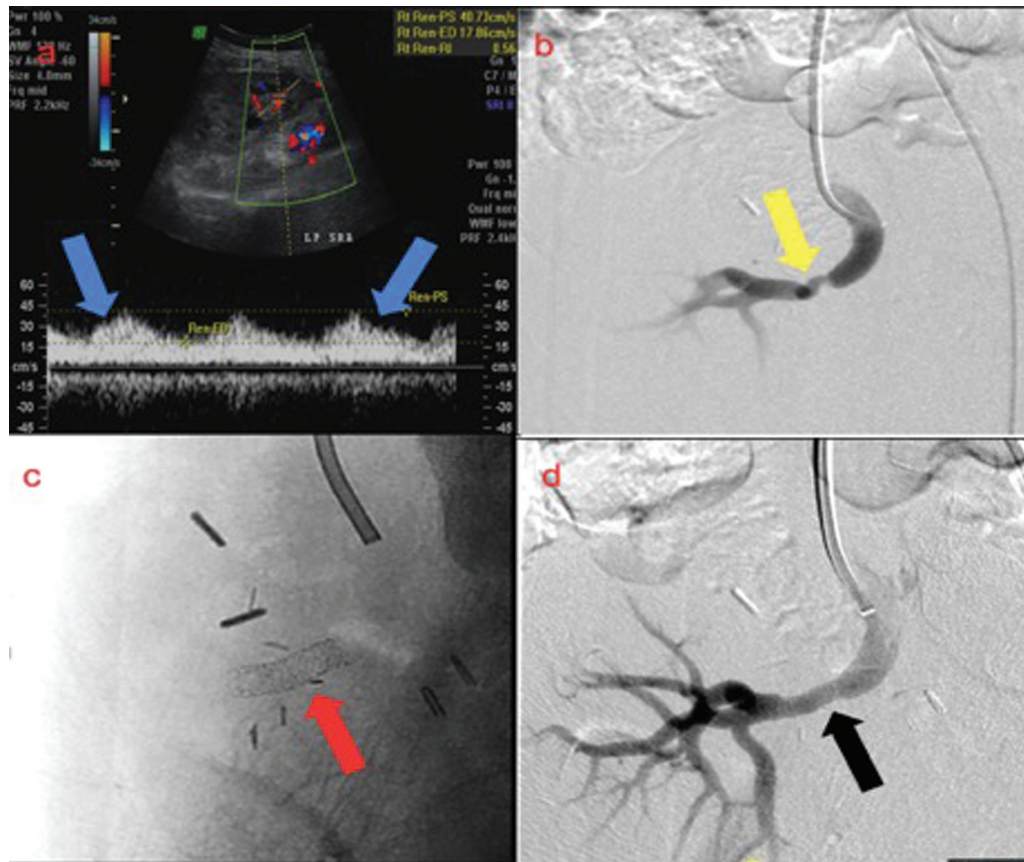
Spectral doppler image (a) of the transplanted kidney shows parvus tardus waveform (blue arrows) in an intraparenchymal renal arterial branch. Selective renal artery digital subtraction angiography (DSA) (b) shows tight focal stenosis (yellow arrow) in the mid-segment of the renal artery. Fluoroscopy image (c) after placement of a balloon expandable bare metal stent (red arrow). DSA post stenting (d) shows a nearly complete revascularization of the transplant renal artery (black arrow).
